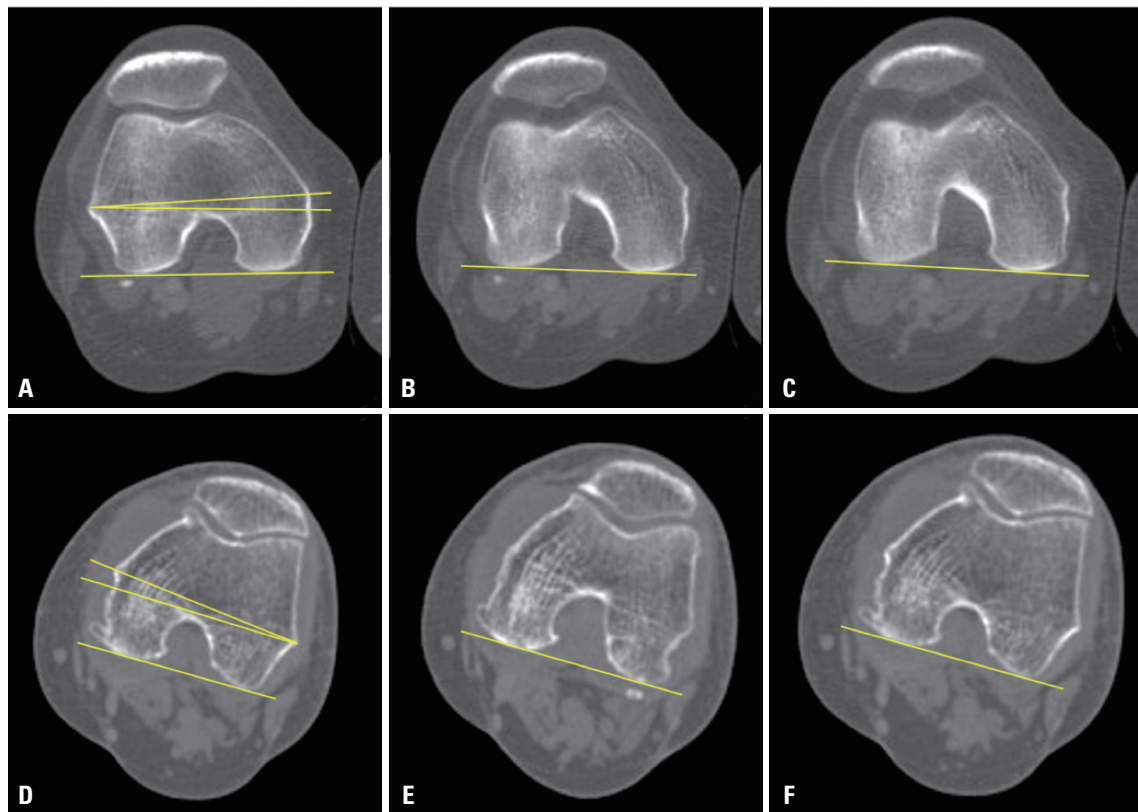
Three different measurement methods of PCA and CTA values on 2D-CT. (A and D) Most protruding TEA section. (B and E) Most protruding PCL section. (C and F) Distal femoral cut section. (A, B, and C) Normal right knee. (D, E, and F) Left knee with osteoarthritis. PCA, posterior condylar angle; CTA, condylar twist angle; 2D-CT, two-dimensional computed tomography; TEA, transepicondylar axis; PCL, posterior condylar line.
